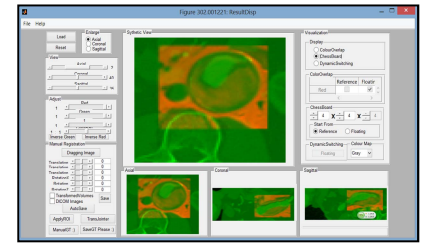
The GUI used to collect manual registration results showing aligned CT-MR volume using overlapped colour channel.
